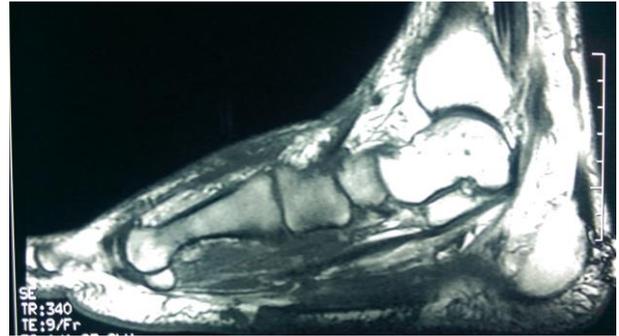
MRI of right foot showing the tarsal inflammatory edema and the base of 1st metatarsal bone with geodes.
